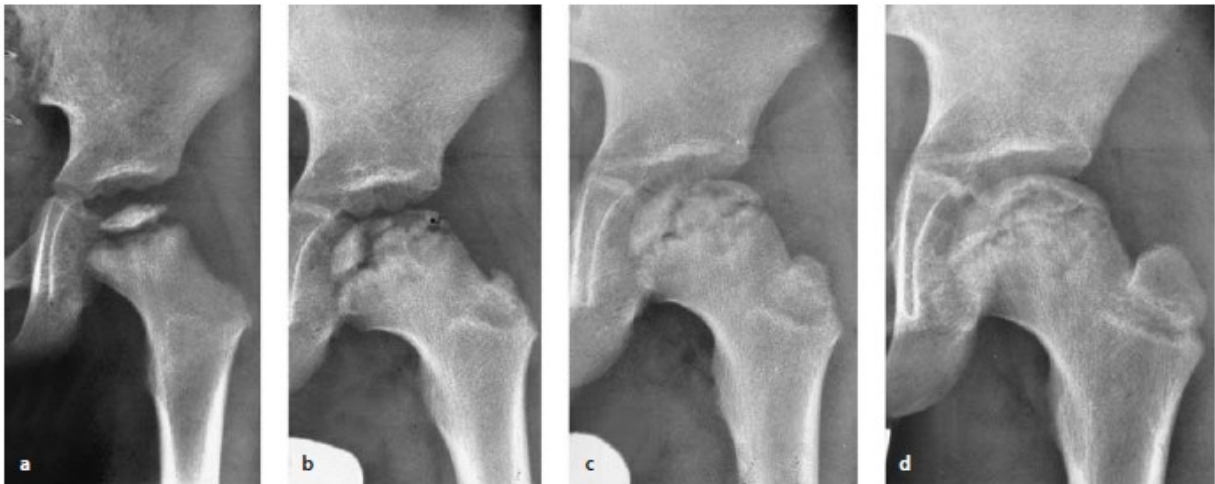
Radiographic progression stages of LCPD: a. boy aged 3 years, femoral head in the condensation stage; b. at the age of 5 years in the fragmentation stage; c. at the age of 7 years in the reparation stage; d. at the age of 9 years in end progress. Hefti et al., 2007 (2)
